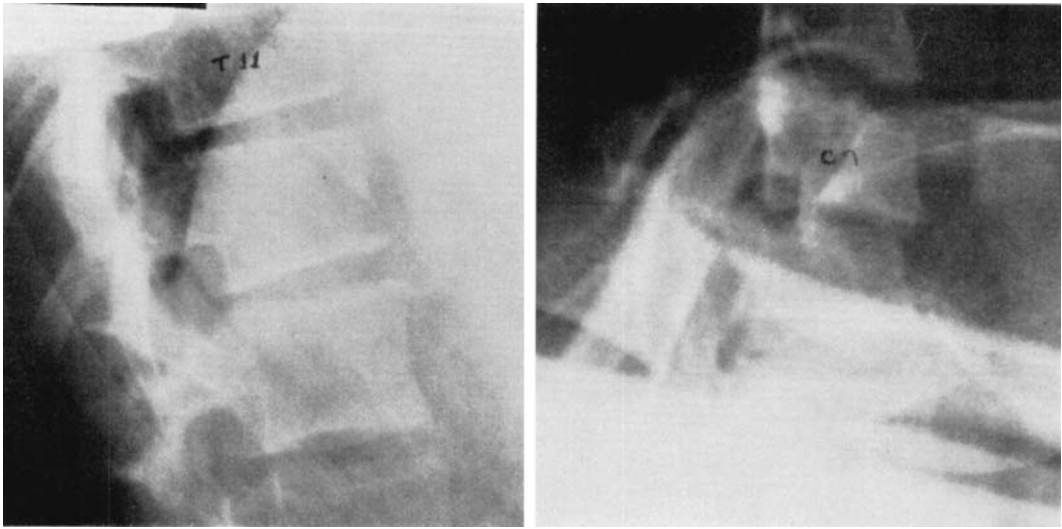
(Case 3). A. Left—x-ray of thoracic spine, taken at time of admission, reveals compression fracture of T_{11} vertebral body. B. Right—x-ray of cervical spine, taken at time of admission, reveals fracture dislocation of C_7 vertebral body on T_1 .
